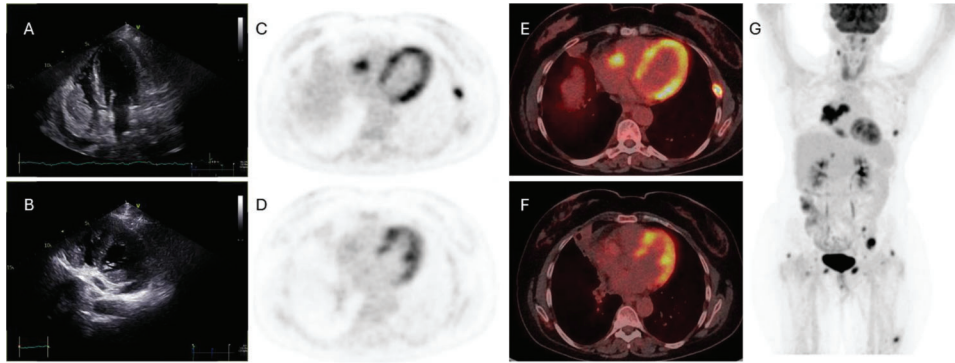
Patient 2 Multimodal imaging of cardiac masses. Panel A: Echocardiography (four-chamber view) showing a mass (*M*) arising from the right ventricle (RV) and right atrium (RA) walls, corresponding to PET/CT findings in Panels C and E. Panel B: Atypical short-axis echocardiographic view demonstrating multiple masses in the papillary muscle, inferoseptal apical segment, and RV wall, all labeled with an asterisk (*M*). Panels D and F: PET scan findings highlighting these cardiac masses. Panel G: Whole-body PET maximum intensity projection (MIP) image revealing FDG-avid right lung malignancy with metastatic involvement of the skeletal system, lymph nodes, right adrenal gland, and heart.
